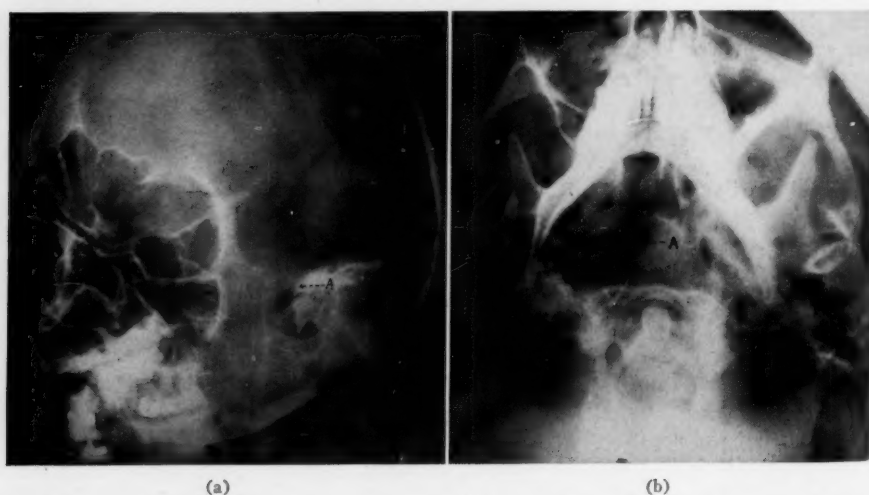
(a).—Case 5: Oblique roentgenogram showing erosion of petrous (A) in 1938. (b) Vertexmental roentgenogram showing erosion and partial destruction of sphenoid bone (A). Left foramen ovale not seen.
